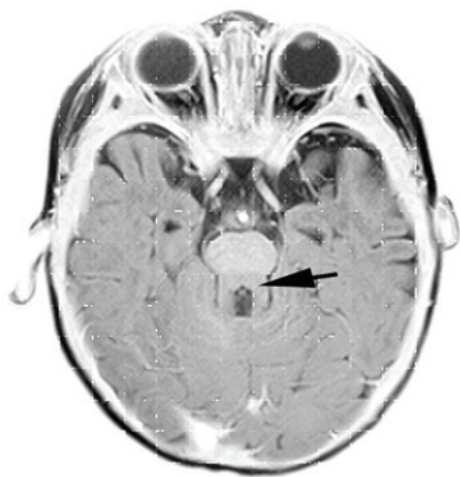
‘Molar tooth sign’ was observed, indicating brainstem abnormalities caused by cerebellar vermis hypoplasia, in the proband through magnetic resonance imaging. The ‘molar tooth sign’ is indicated by an arrow.
